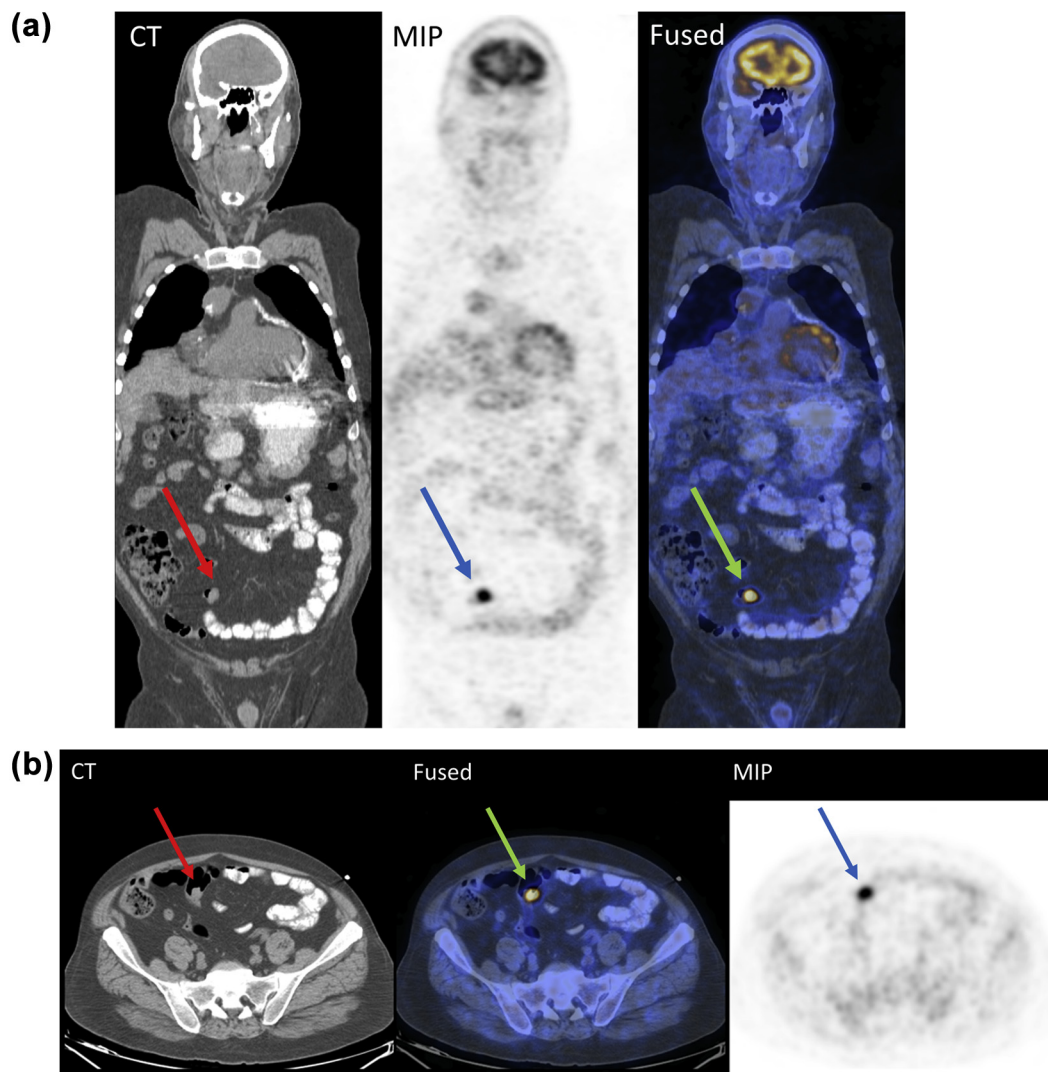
Example of positive 18 fluorodeoxyglucose–positron emission tomography/computed tomography (FDG-PET/CT) for extra-cardiac finding in a 60-year-old man with left ventricular assist device and *Streptococcus bovis* infective endocarditis. The FDG-PET/CT shows an abnormal uptake in the right colon (arrow), revealing a neoplasm that was confirmed as villous adenoma by colonoscopy and no uptake around the device. This finding was presumed to be the port of entry for the bacteraemia. The FDG-PET/CT images are presented as cranial (a) and sagittal (b) sections and in CT, fused and attenuation-corrected maximal intensity projection images.
